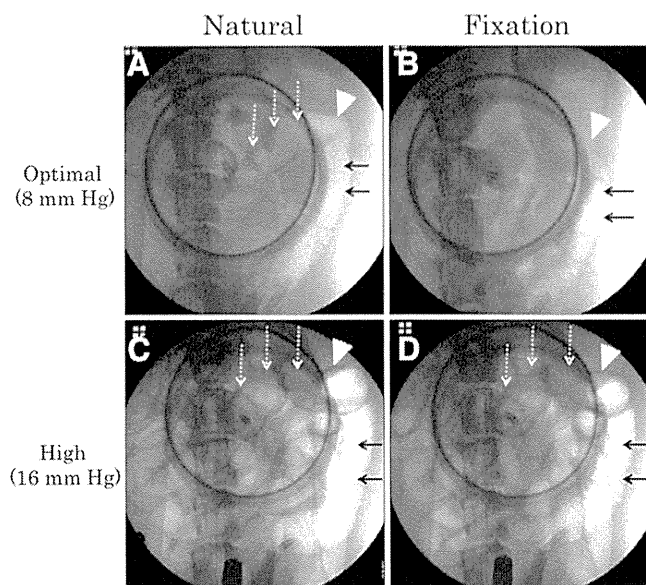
X-ray images obtained immediately after the insufflation trials for each condition in experiment 2 were completed. Arrowheads indicate each flexure point. Note the distended tracts with migrated gas on the cecal (proximal) side (dotted arrows) and the rectal (distal) side (solid arrows). A, In the natural model with optimal insufflation pressure, gas migration was observed in the oral tract around the cecum. B, In the fixation model with optimal insufflation pressure, gas migration was confirmed only at the rectal side of the colon; gas was not observed at the oral side beyond the flexure point. C, In the natural model with high insufflation pressure, gas migration was observed in the oral tract around the cecum and the distal ileum. D, In the fixation model with high insufflation pressure, gas migration was confirmed at the oral side beyond the flexure point around the cecum.
